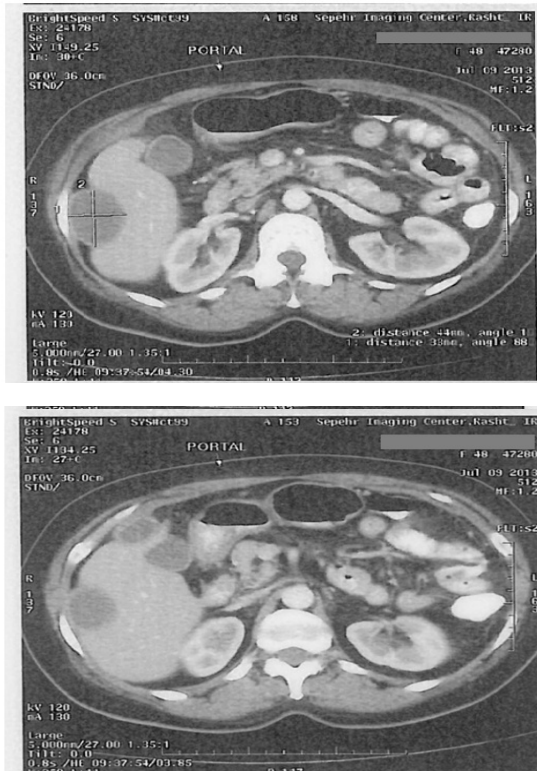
CT scan of the abdomen showing well-defined hypo-dense masses in the right liver lobe.
